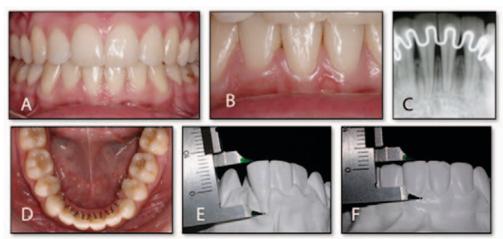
A. Final intraoral photograph (frontal view). B. Close-up of treatment area. C. Periapical radiograph with lingual retainers in place. D. Occlusal view with lingual retention. E. Measurement of gingival defect on diagnostic cast before surgery and orthodontic treatment showing 9.0 mm total length. F. Measure of clinical crown showing 5.0 mm distance with confirmation of 4 mm of gingival coverage of root recession.
